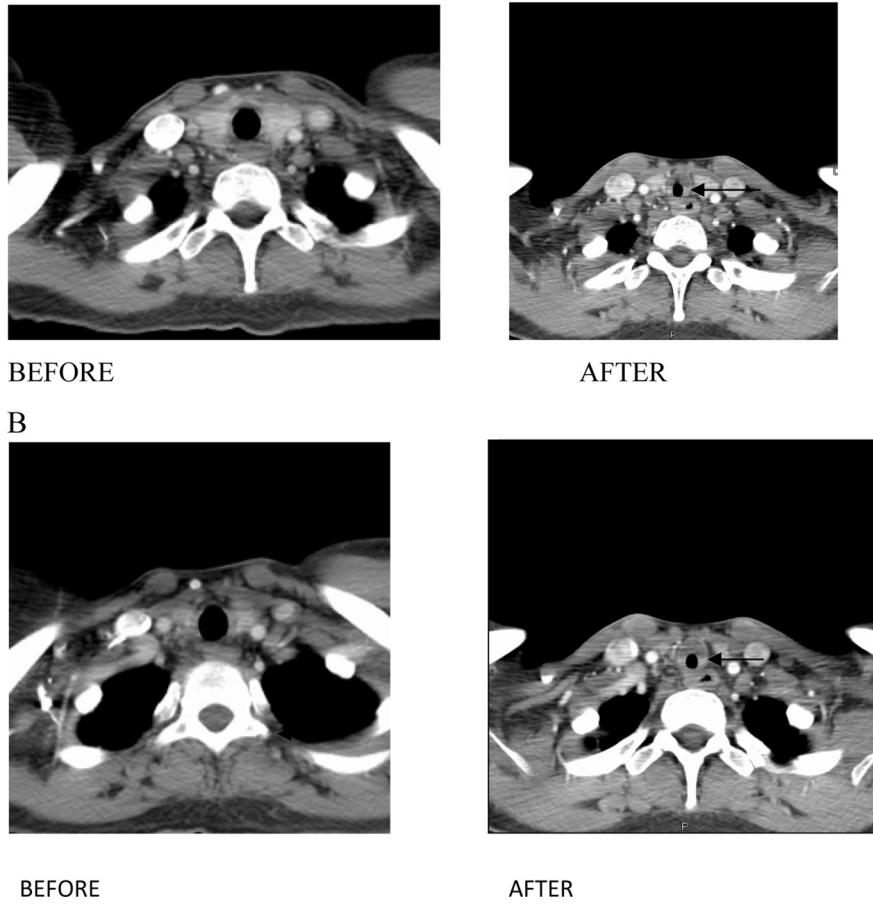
(A, B). CT images of the soft tissue neck with contrast shows area of narrowing in the trachea above the level of the thoracic inlet (arrow). The lesion is localized in the extrathoracic trachea, adjacent to the level of the thyroid gland, about 3.5 cm below the vocal cords.
